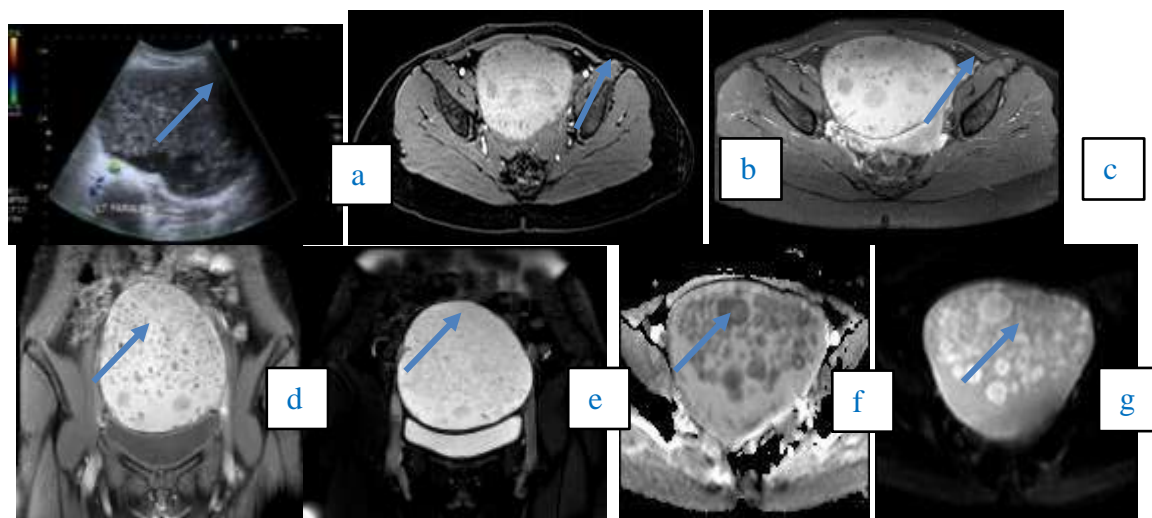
Grey-scale US image (a) showing a large complex (cystic and solid), avascular left adnexal mass with multiple internal echogenic foci. MRI axial T1WI (b) pre- and (c) post-contrast showing a non-enhancing predominantly high T1 signal lesion with innumerable variably sized and shaped floating debris contents which are hypointense on both T1 and T2-weighted imaging. (d) Coronal T2-weighted imaging and (e) T2 fat suppression shows predominantly high T2 signal with no suppression on fat suppressed sequence. There is no diffusion restriction in (f) diffusion-weighted-imaging (DWI) and (g) apparent-diffusion coefficient (ADC) map.
